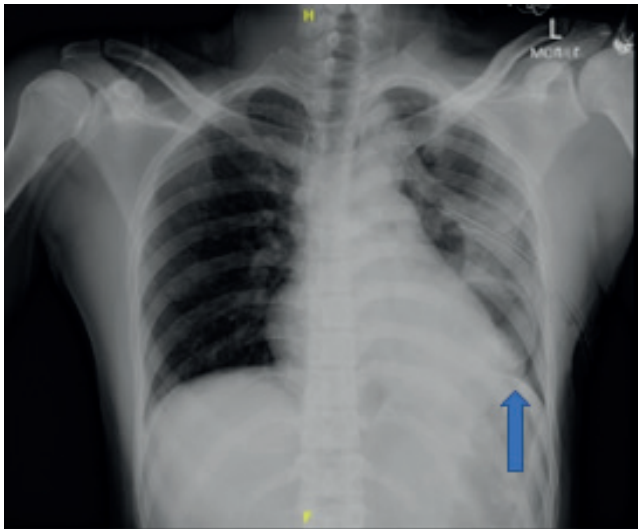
Chest x-ray post left chest tube insertion shows left chest tube in site, residual left pneumothorax and a rounded hyperdense ring seen in the left lower zone (blue arrow)
